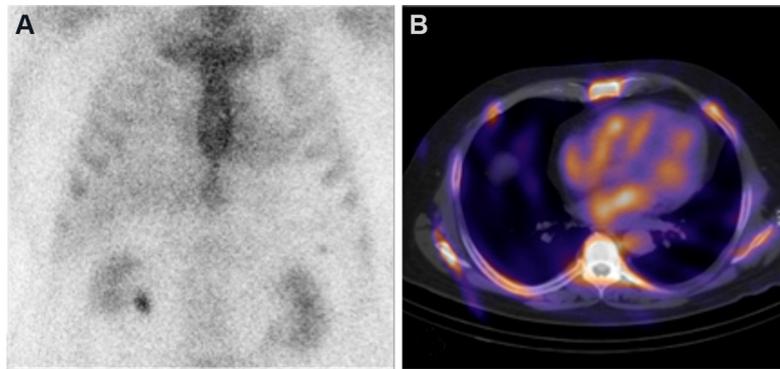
Technetium-99m pyrophosphate bone scan: (A) mild tracer uptake that overlaps the cardiac area on planar images; and (B) single photon emission computed tomography/computed tomography images show no uptake on heart walls.
